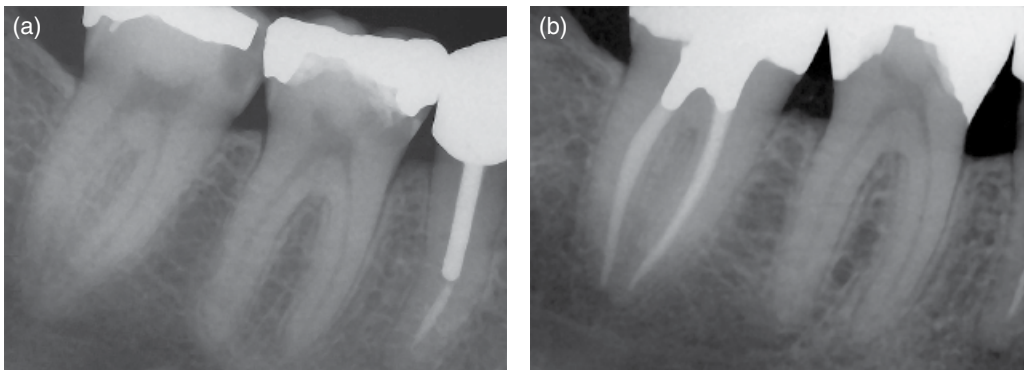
Radiograph (a) showing two lower molars both with extensive and deep carious lesions. Patient complained about severe pain of few days duration but was unable to determine which tooth was causing the pain. Pulpal tests were inconclusive on which tooth had more severe pulpal inflammation. After caries excavation a caries perforation was found in the second molar but not the first. The second molar was treated with root canal therapy. The first with vital pulp therapy and restoration. (b) At one year re-evaluation the first molar responded normally to pulpal tests and both teeth were normal to percussion and palpation.
